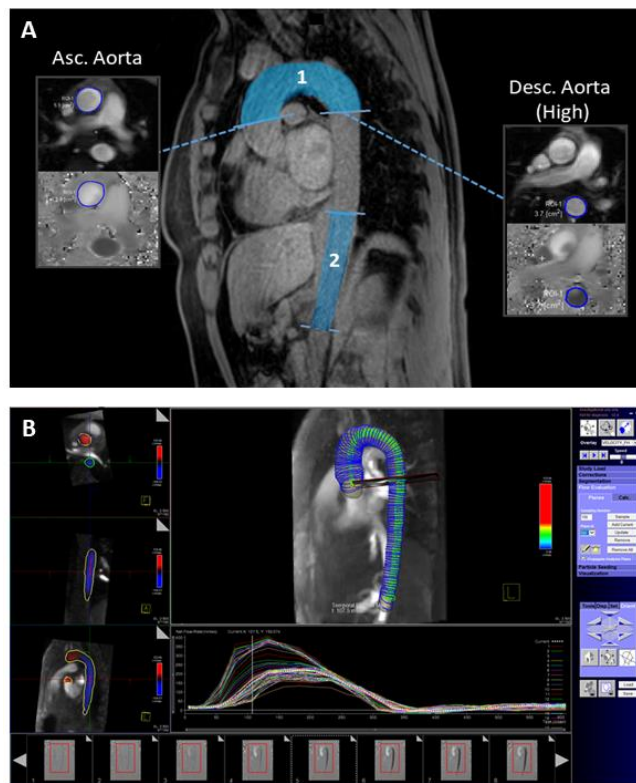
1 (A) 2D PC MRI data acquisition strategy. The two aortic regions, i.e. the aortic arch (1) and the descending aorta (2), are highlighted with blue. The corresponding 2D imaging planes are shown. The PC data for the ascending aorta and the descending aorta at the level of the pulmonary artery as processed with the software Segment (Medviso) are depicted. (B) Processing of the CS-4D MRI data using 4D Flow Demonstrator (Free-type Project, Siemens Healthineers, Erlangen, Germany)
